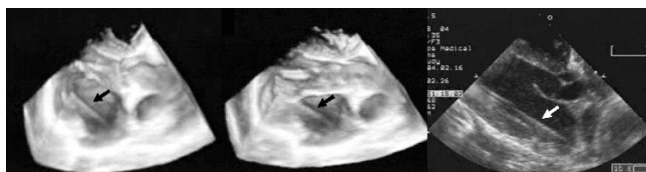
Echocardiographic images showing the surgical instrument (2 mm, arrows).
